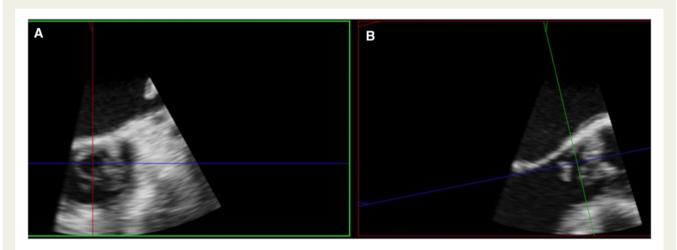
Transoesophageal aortic short-axis view (multiplanner review) with (A) abscess of the non-coronary cusp. (B) Transoesophageal aortic long-axis view to demonstrate the cross section.
